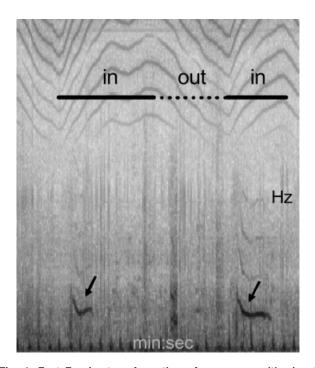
Fast Fourier transformation of sonogram with signal derived from Respitrace belt superimposed above to show phase of respiration. Oscillator controlled by Respitrace generated a signal with many harmonics. Acoustic record shows monophonic inspiratory wheezes (arrows), with faint harmonics on two consecutive breaths. Scale on vertical axis is in Hz, and on horizontal axis in minutes and seconds.
